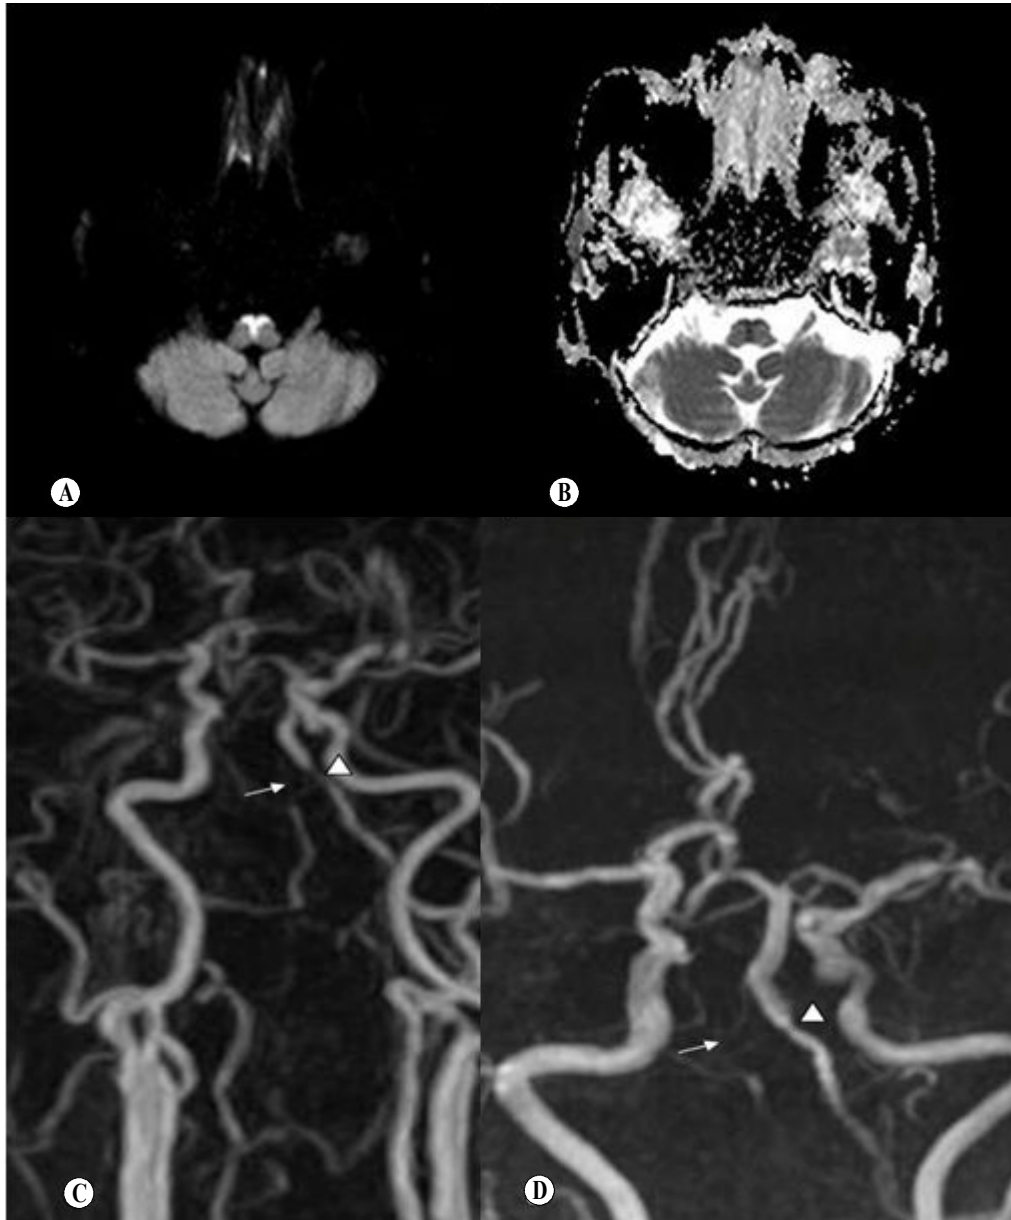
Magnetic resonance imaging of a 78-year-old woman with sudden onset of tetraparesia. Diffusion-weighted imaging shows a hyperintense lesion at the medulla oblongata which demonstrates a classic “Heart appearance” (A). Apparent diffusion coefficient map demonstrates reduced diffusion (B). Contrast-enhanced (C) and time-of-flight magnetic resonance angiography (D) show an occlusion or a severe stenosis of the right vertebral artery (arrow) and a stenosis of the left vertebral artery (arrowhead).
